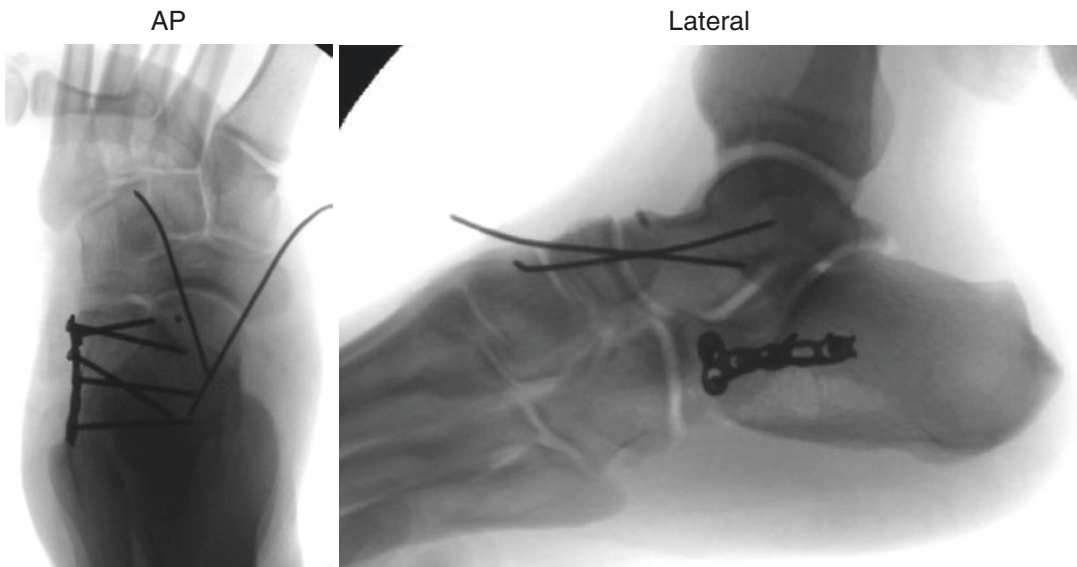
Radiographs of the final fixation construct; two retrograde 0.62 Kirschner wires are through the talonavicular joint and a laterally based T-plate at the anterior process of the calcaneus
